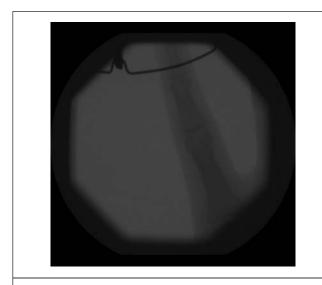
Post-reduction x-ray (with traction)
